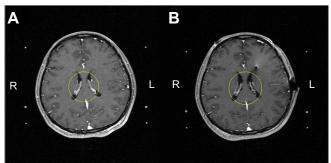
T1-weighted double-dose gadolinium-enhanced brain MRI scans of a 42-year-old female patient treated with levodopa for 17 years, presenting with aggravated peak dose dyskinesia.
